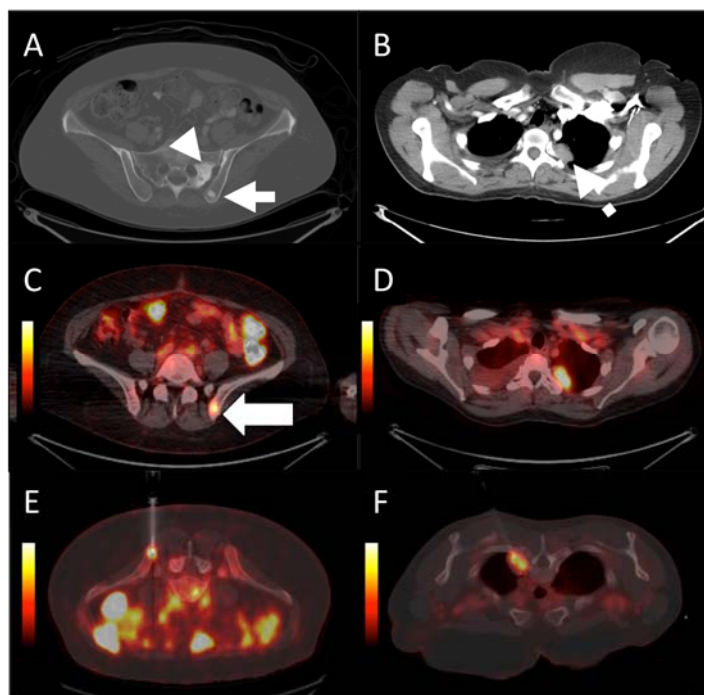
Delayed molecular imaging PET/CT-guided biopsies of a bone and lung metastases of breast carcinoma
